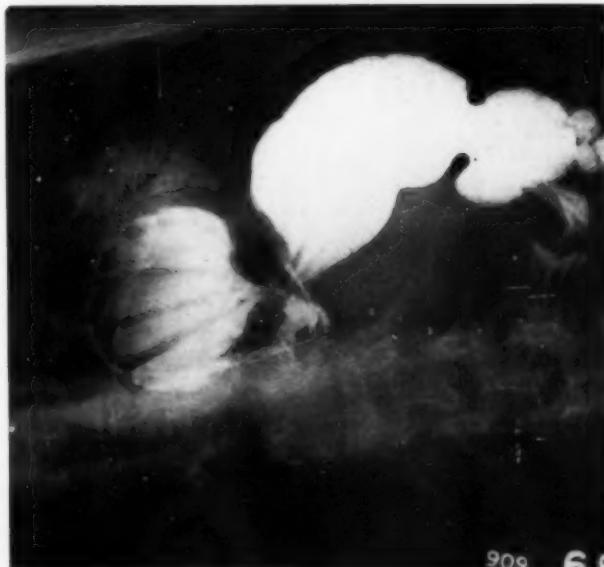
Roentgenogram showing a large paraesophageal hernia.
